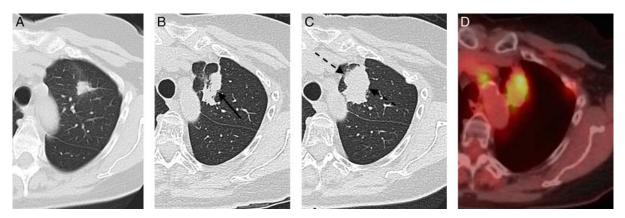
SBRT recurrence. A, Baseline contrast-enhanced axial CT shows left upper lobe adenocarcinoma, which was subsequently treated with SBRT. B, Follow-up contrast-enhanced axial CT, 2 years post-SBRT, shows opacity at the site of treated tumor larger than original tumor, but with a non-mass-like appearance (black arrow). C, Follow-up contrast-enhanced axial CT at 2.5 years post-SBRT shows increase in overall size with loss of air bronchograms and new bulging margins (black dashed arrows), suspicious for recurrence. D, Fused axial PET/CT at 2.5 years shows corresponding FDG avidity, raising further suspicion for recurrence. [full complete text]
